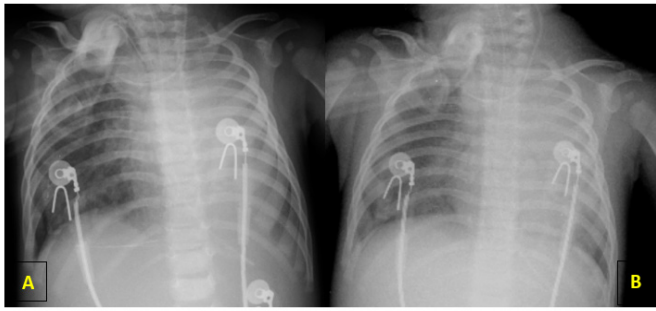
Chest X-ray when the patient with LMA (A) and after tracheostomy performed (B)
